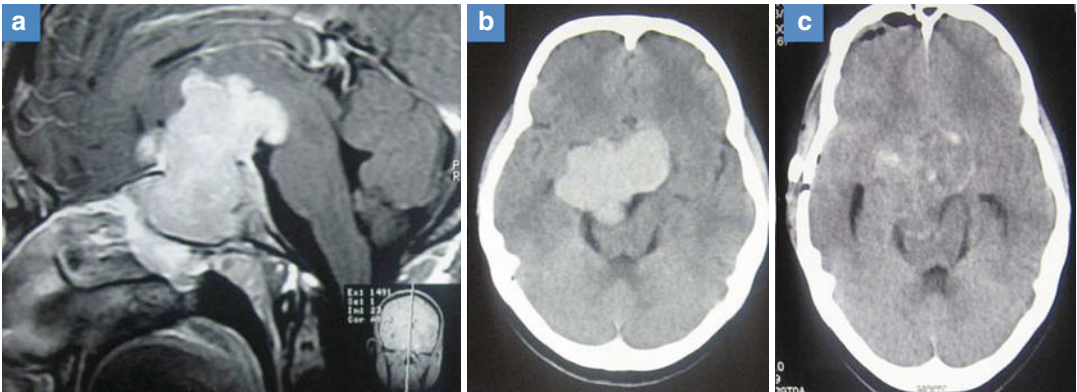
Sagittal contrast-enhanced MRI (a) and CECT head (b) showing a giant pituitary adenoma with parasellar and subfrontal extensions. Figure (c) showing postoperative pituitary apoplexy in the residual tumour
